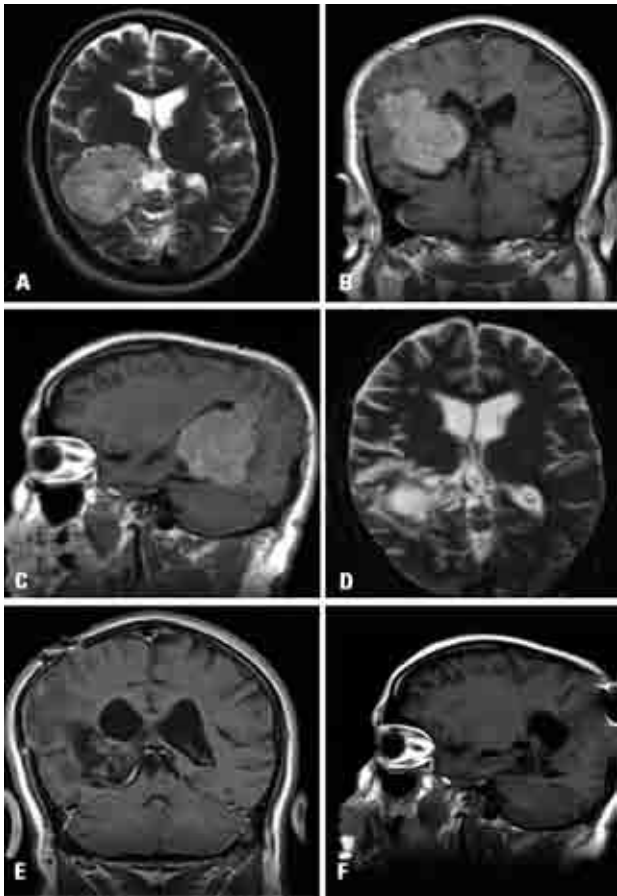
Case 4. A 45-year-old man with progressive decline of visual acuity. [A B and C] Pre-operative MRI. [D, E and F] Post-operative MRI after 2 years showed no residual tumor.
